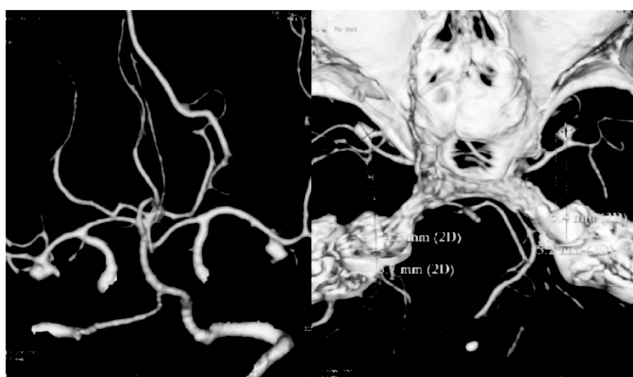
Case (2) 51 years old lady presented with focal deficits. Brain CT was normal but CTA (volume rendering technique) shown bilateral saccular aneurysms involved middle cerebral artery at its bifurcation into opercular branch (distal M1segment) into right and left temporal region; the right one measure 5.5x4.5mm and the left one measure 5.5x5mm.
